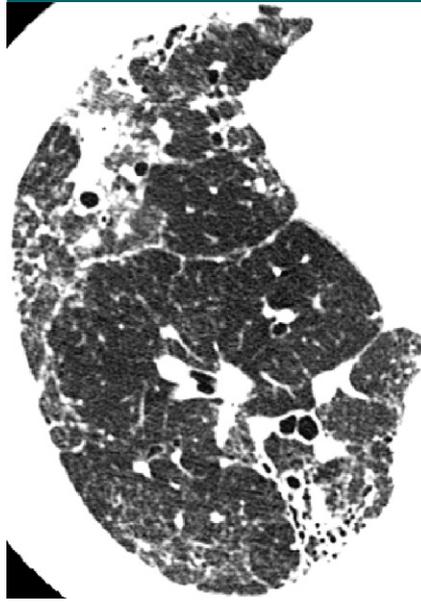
UIP or NSIP pattern in a 73-year-old man. Transverse thin-section (0.5-mm) CT image through the right lower lobe shows ground-glass opacity, intralobular reticular opacity, and traction bronchiectasis. Impression of CT findings was heterogeneous, and the findings were not in a predominantly peripheral distribution. Pathologic diagnosis of UIP was made.
